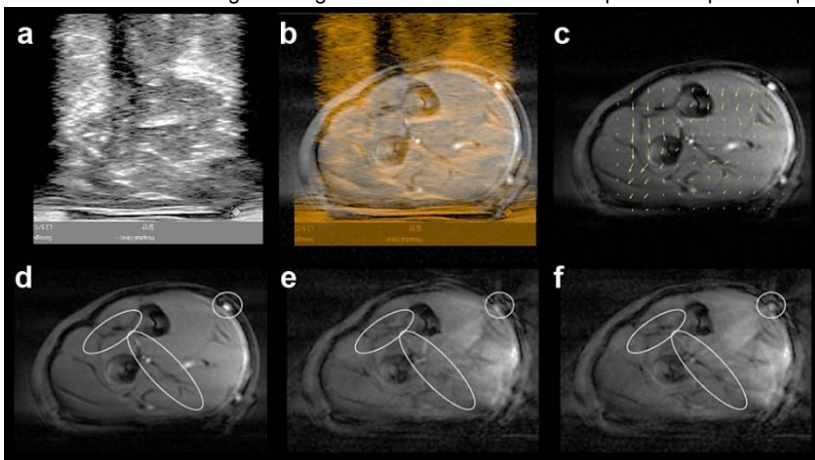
Experimental results. (a) cross-sectional US image frame of the subject's right-arm, (b) superimposed image of US and MR, (c) estimated motion vectors, (d) MR image acquired without motion, (e) motion-distorted uncorrected MR image, (f) the corrected image. Three distinct features that are severely distorted in the uncorrected image (e), but substantially recovered in the corrected image (f) are indicated by ellipses.
